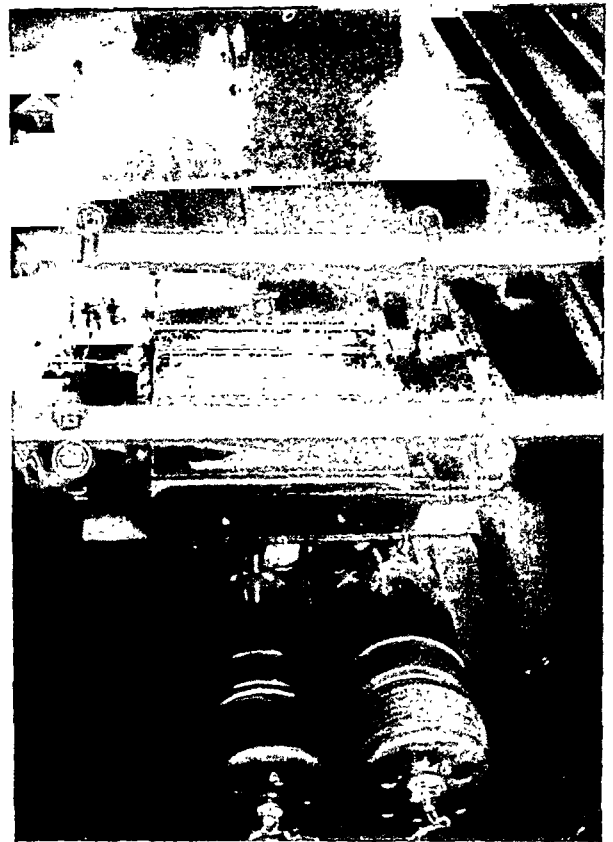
Roentgenologic tilt table top removed showing the triangulation roentgenoscopic assembly. Note roentgen tubes in parallel. Three wire system to the cathodes, one wire common. Anode, one wire with short wire connecting the two anodes. One tube set so that rays are at right angle to the table top as for conventional roentgenoscopy, the other tilted slightly so that rays intersect those of the first tube for triangulation roentgenoscopy. The first tube can be used independently of the second tube by a single switch on the control panel.
